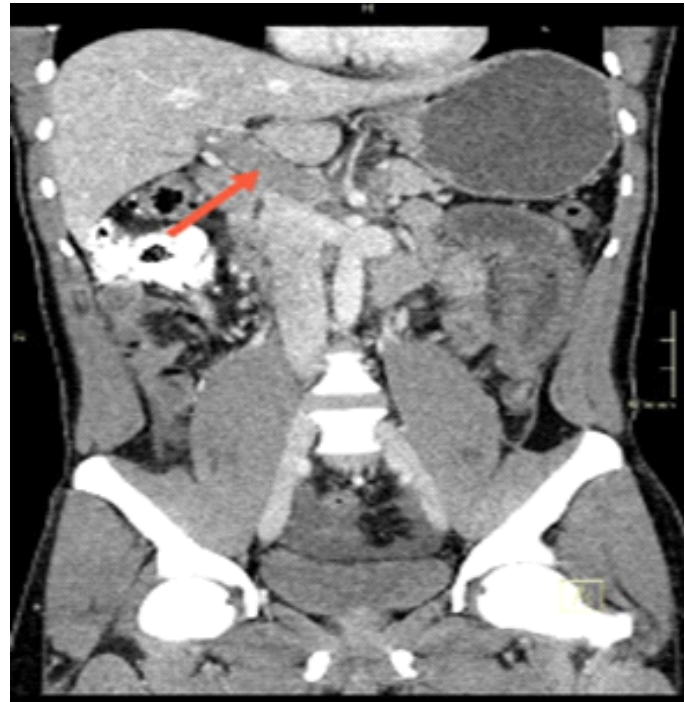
CT image showing portal vein thrombosis
